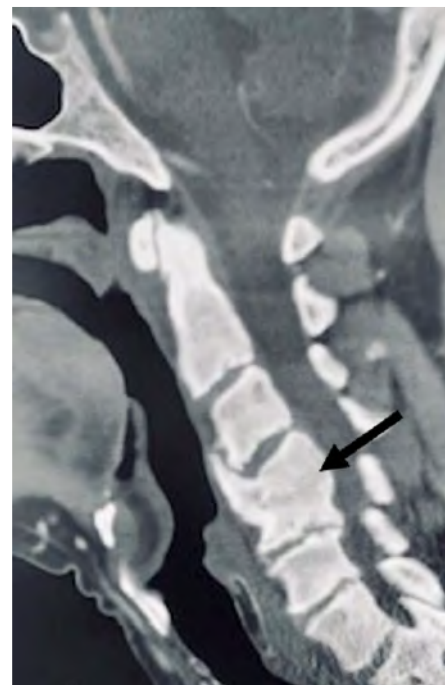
Computed tomography scan of sagittal plane of cervical spine showing fourth and fifth cervical fusion (arrow) two years after initial presentation.
